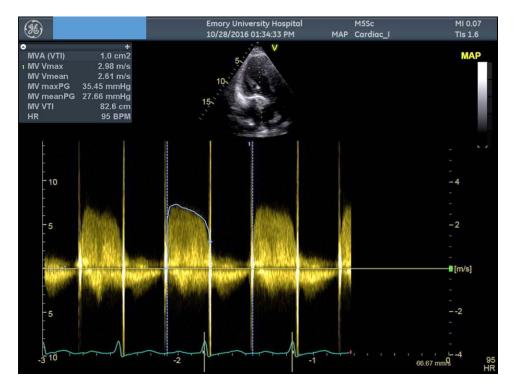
Continuous-wave Doppler reveals the severely elevated MV meanPG 27 mm Hg across the MMV suggesting severe mitral valve stenosis (TTE at 24 wk). Normal MV meanPG is <5 mm Hg, and MV meanPG >10 mm Hg suggests severe mitral stenosis. MMV indicates mechanical mitral valve; MV meanPG, mitral valve mean pressure gradient; TTE, transthoracic echocardiography.
